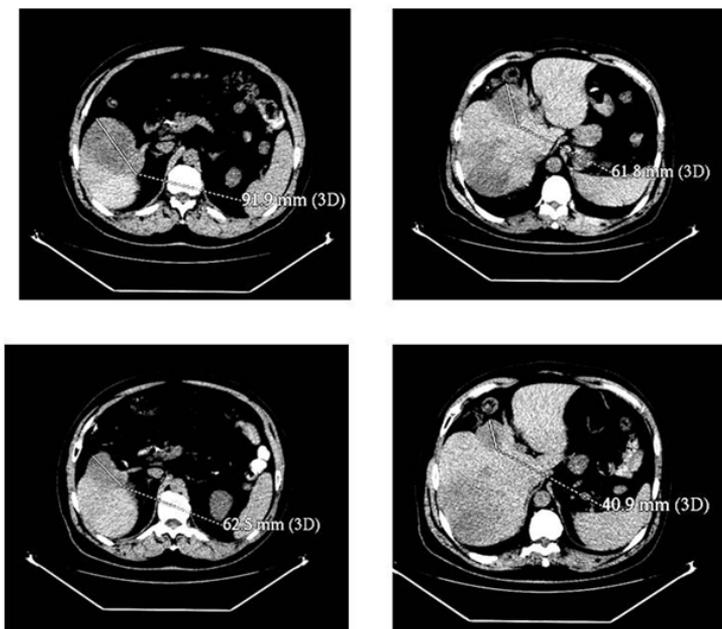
Pre and posttreatment axial CT images of patients who received 1.6 GBq Y^{90} microspheres treatment for neuroendocrine tumor liver metastases revealed partial response.
